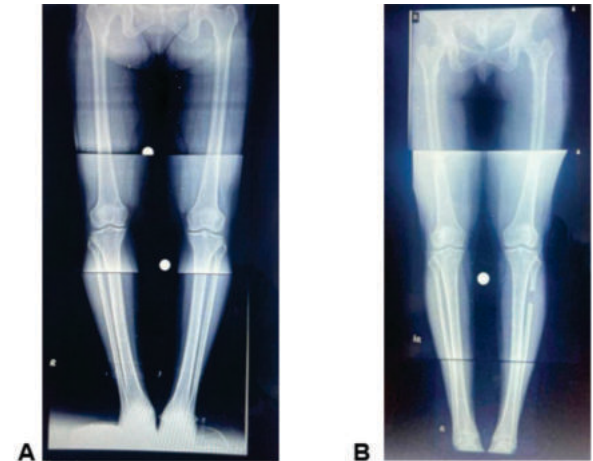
Shows The (a) Pre-operative And (b) Post-operative X-ray
